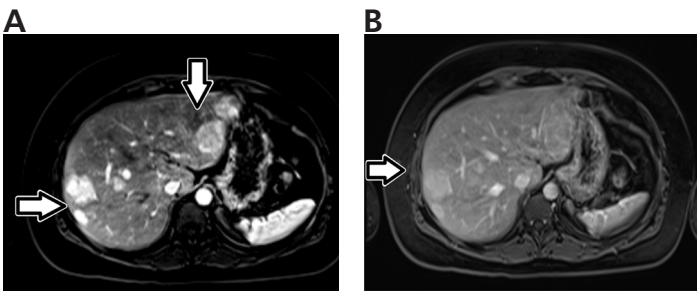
Contrast enhanced MRI also demonstrating similar features as CT scan with arterial enhancement (2A) and portal venous washout (2B).
